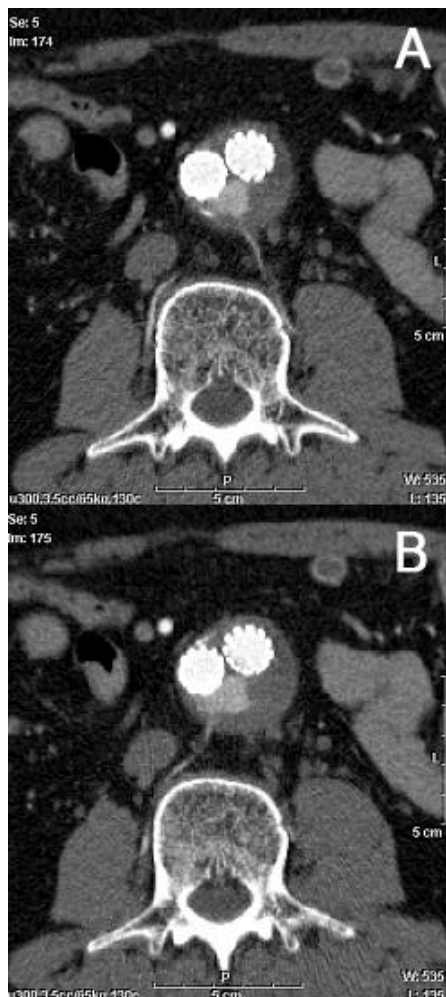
Abdominal CT shows type II endoleak supplied from both lumbar artery (arrows) just below the level of stent-graft bifurcation.
